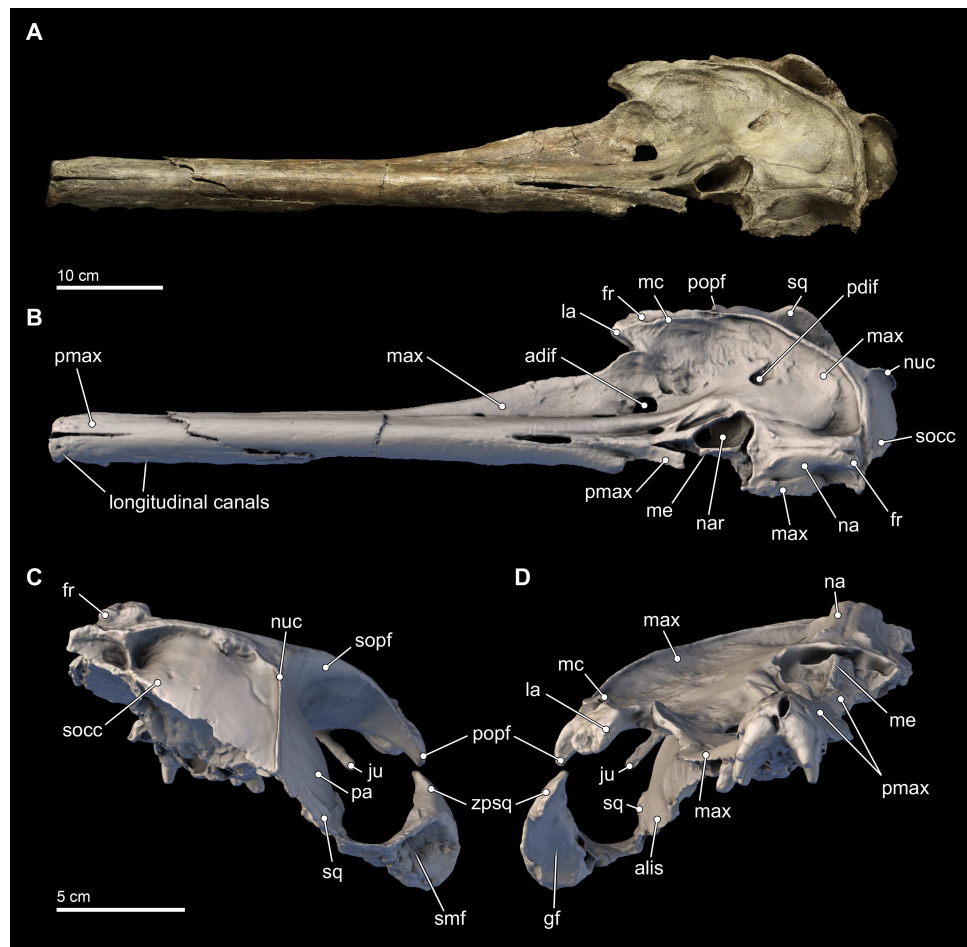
Skull in dorsal, anterior, and posterior views. Dorsal views of the type skull of *Isthminia panamensis* (USNM 546125) from (A) photographs and (B) orthogonal digital three-dimensional polygon model prepared from CT data, with lighting and color modifications using the Smithsonian X 3D browser. (C) Anterior and (D) posterior views of the type skull of *Isthminia panamensis* (USNM 546125) from orthogonal digital three-dimensional polygon model prepared from CT data. See <http://3d.si.edu/explorer?s=h2mqj9> (dorsal view), <http://3d.si.edu/explorer?s=bA5gJO> (posterior view), and <http://3d.si.edu/explorer?s=e1seD5> (anterior view) to measure, modify, or download this model.
